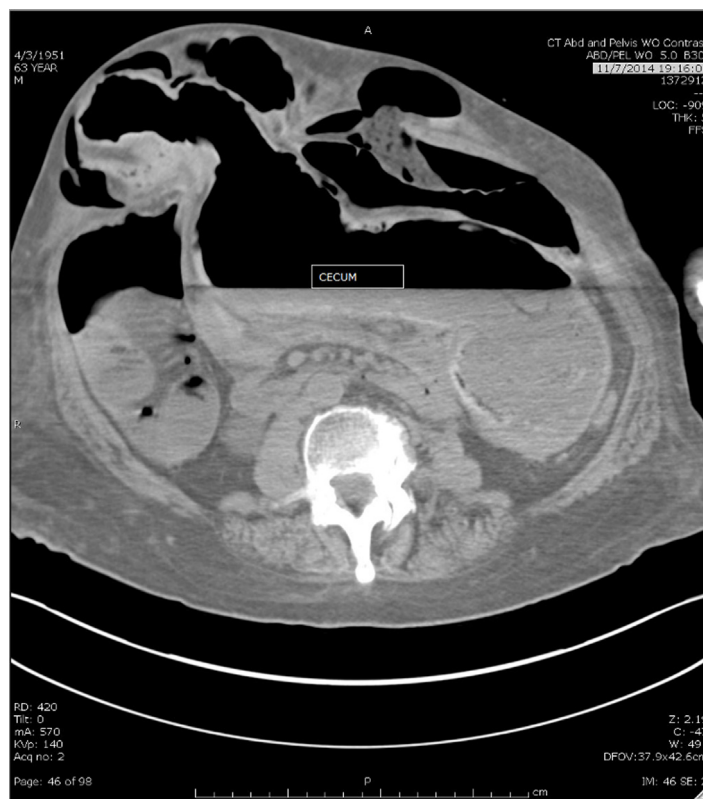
CT axial view showing markedly distended cecum, partially contained in the ventral hernia.
